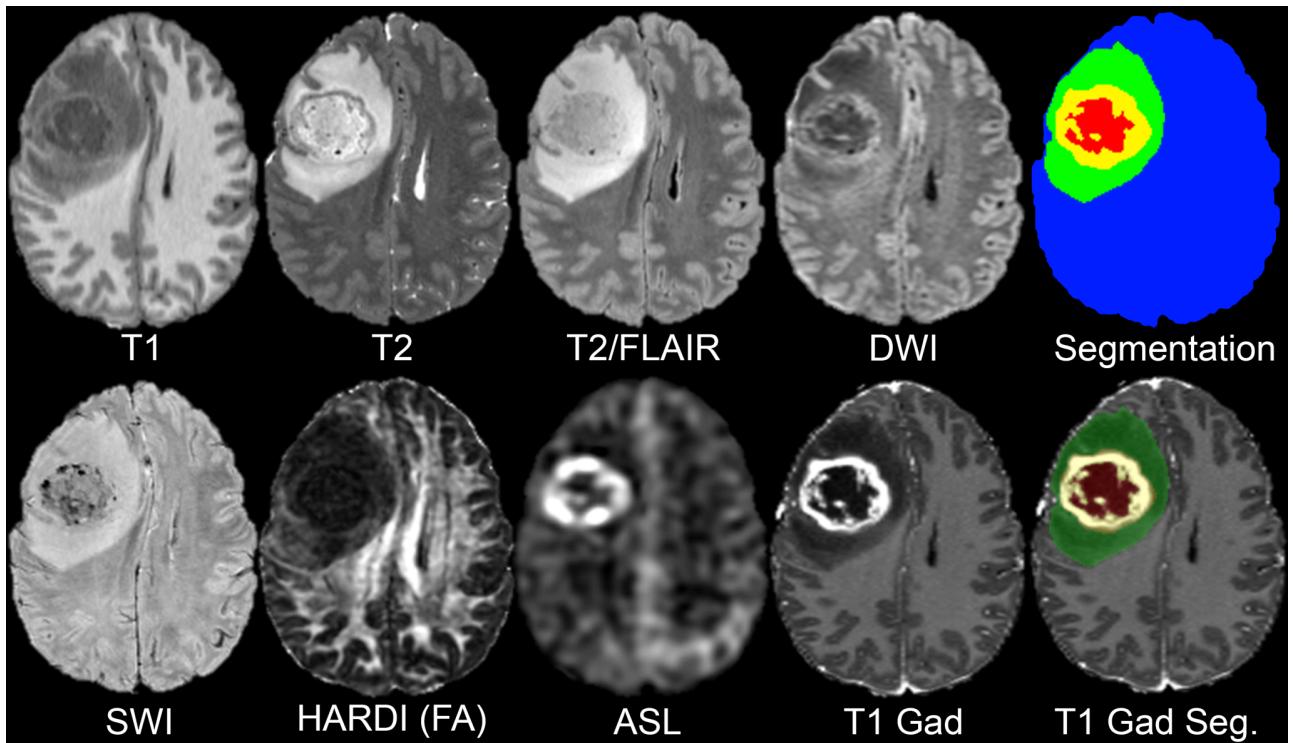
The expected output from the segmentation task. The image shows various brain scans using different MRI imaging techniques and finally, the coloured image shows the segmented tumour. The Blue section stands for Healthy Tissue, Green section for Edema, Yellow section for Enhancing Tumour and Red section for Necrotic Tissue.
